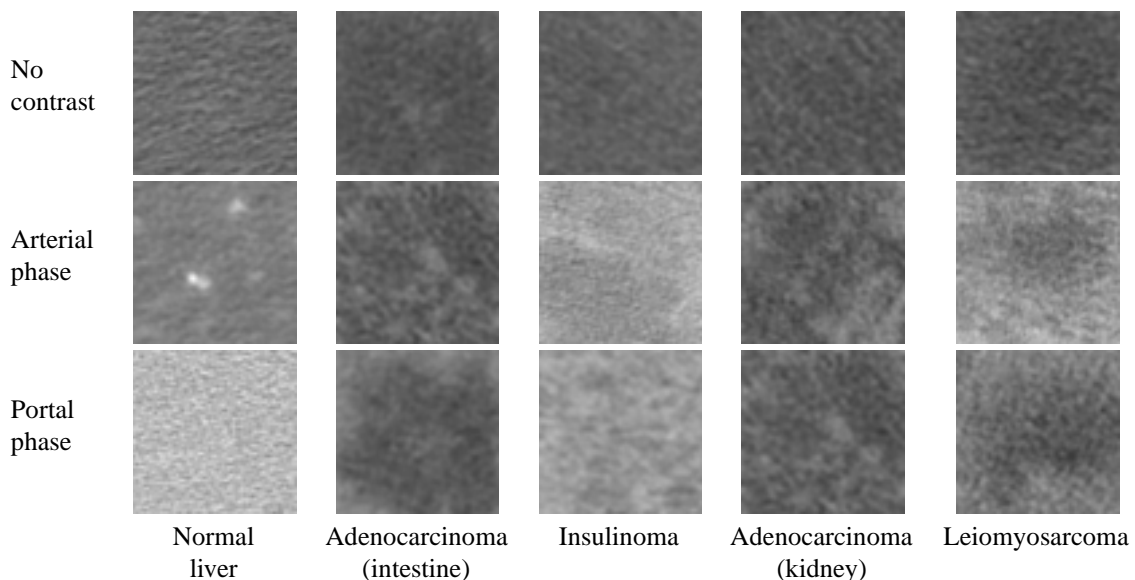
Examples of analyzed textures (normal tissue and 4 types of metastasis) extracted from dynamic CT images acquired before injection of contrast product and during its propagation (arterial and portal phases)
